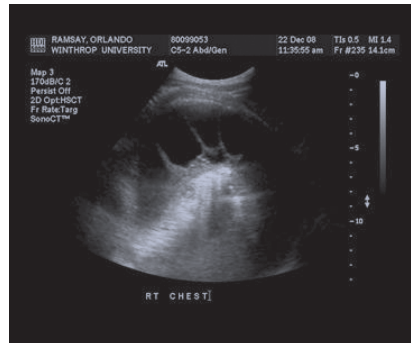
A loculated pleural effusion is seen on ultrasound performed to evaluate the consistency of pleural fluid.
